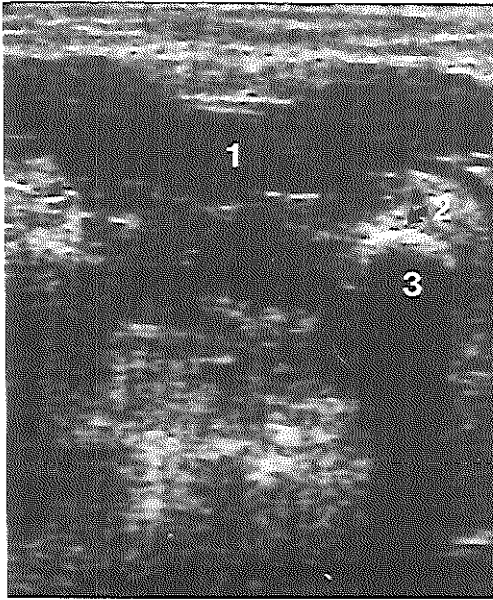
Transverse sonographic section in the midline of the floor of the mouth. A stone in the submandibular duct is visualized as a strong reflection with an acoustic shadowing.
